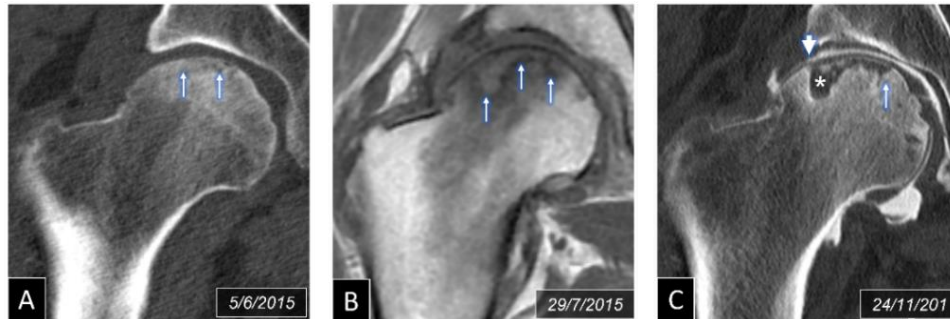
ONFH in a 37 yo man with renal transplant. (A) Coronal MDCT reformat shows trabecular interruption (arrows); also note the heterogeneous density of the femoral head. (B) Coronal T1-weighted MR image shows the osteonecrotic lesion (arrows) without collapse of the articular surface. (C) Coronal reformat of CT arthrogram (5 months later) shows progression of collapse-related bone changes: cortical interruption (arrowhead), trabecular interruption (arrow) and bone resorption (asterisk).
